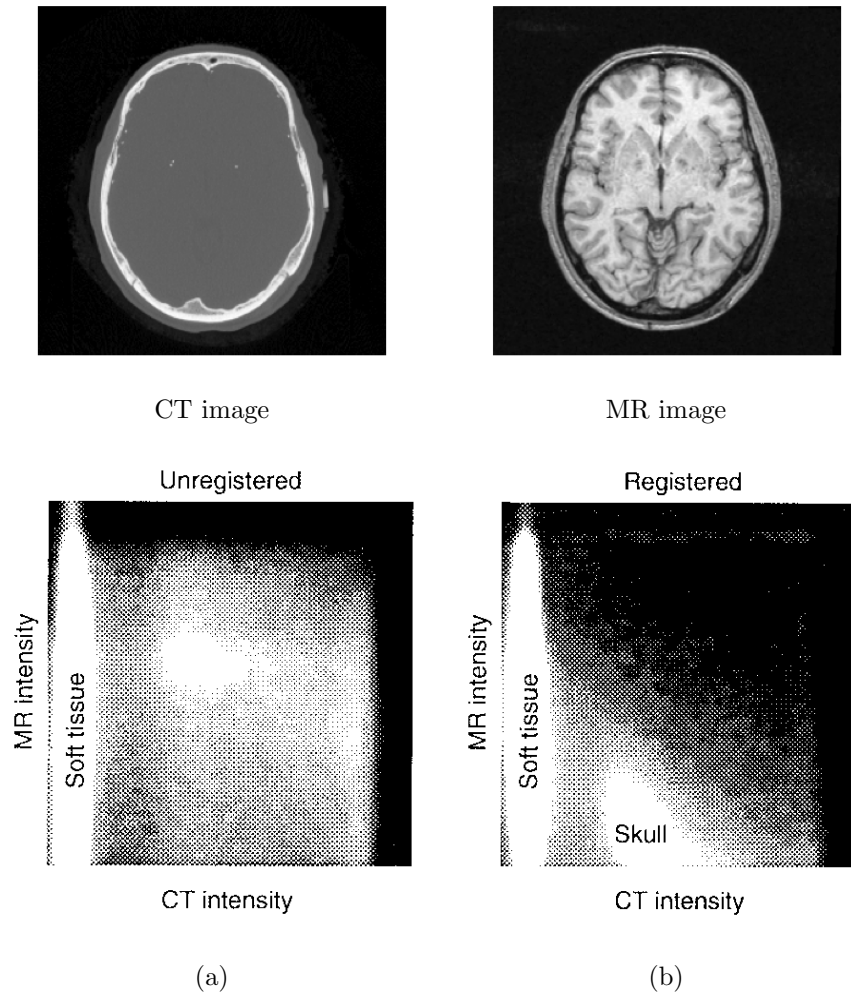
Joint intensity histograms of a CT image and MRI image of the head showing the case when a) the images are not registered and b) the images are correctly registered (adapted from Maes *et al.*, 1997). Each point in the 2-D histogram is a count of the number of overlapping pixel pairs that have the corresponding intensities (CT intensity in one pixel and MR intensity in the other). If the images were identical the joint intensity distribution would be concentrated along the diagonal. In this example areas in the MR image have a range of intensity values for the centre of the head compared to the a uniform intensity in the CT image. The images are registered when the dispersion (entropy) of the joint intensity distribution is at a minimum.
